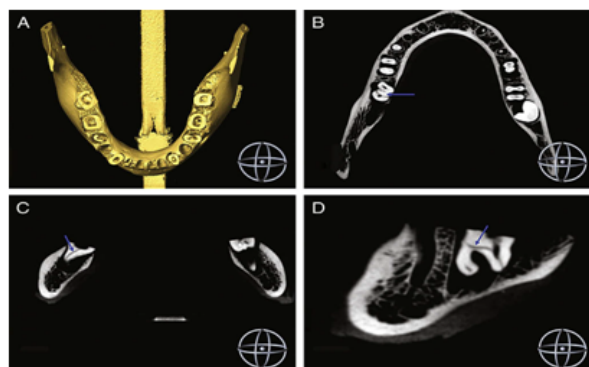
I-CAT CBCT reconstructions. (A) Three-dimensional surface reconstruction of the mandible. Fracture line is visible on 2D slices (arrow). (B) Axial, (C) coronal, and (D) sagittal.
